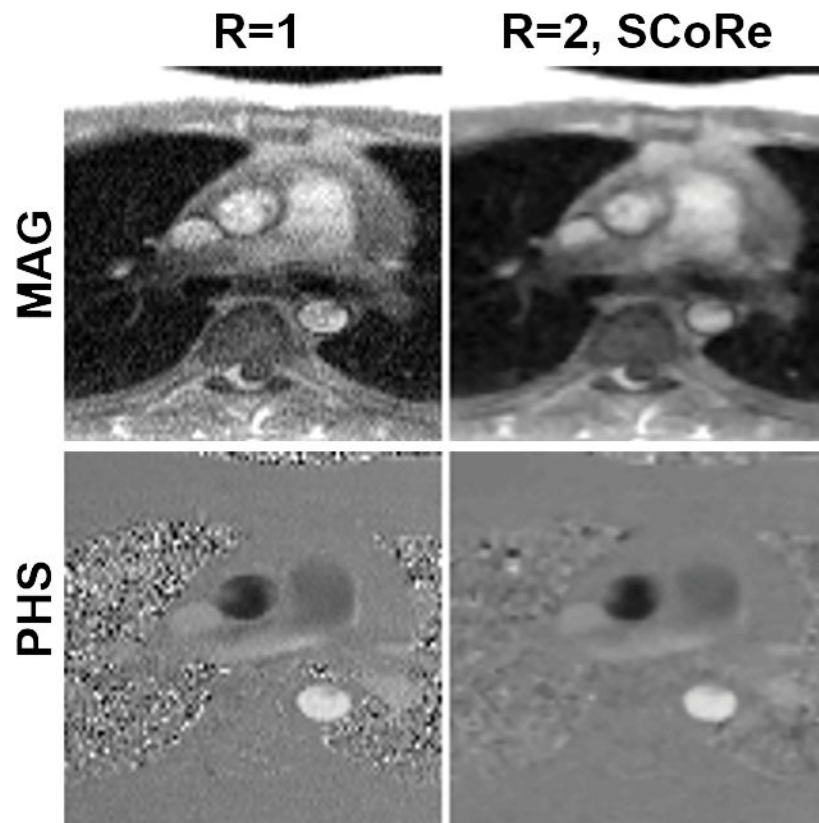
Phase-contrast MRI images from the data collected on a 0.35T scanner. A fully sampled dataset was acquired using the following parameters. Matrix size: 192×108 ; FOV: 350×262 mm²; TE/TR: 2.6/6.5 ms; slice thickness 8 mm; flip angle: 25°; bandwidth: 389 Hz/pixel; temporal resolution 52 ms; number of averages: 3; FLASH-based prospectively triggered segmented sequence. For R=1, image recovery was based on the inverse Fourier transform of k-space data followed by sum-of-squares coil combine. For R=2, the data were retrospectively downsampled with VISTA, and the image recovery was based on SCoRe. Note, for R=2, no averaging was employed.
